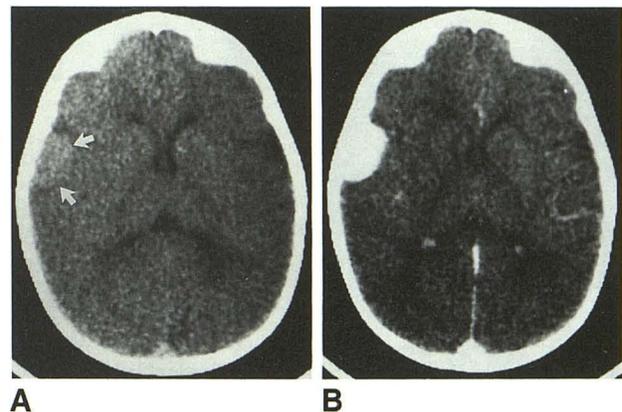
CT without (A) and with (B) intravenous contrast infusion.
